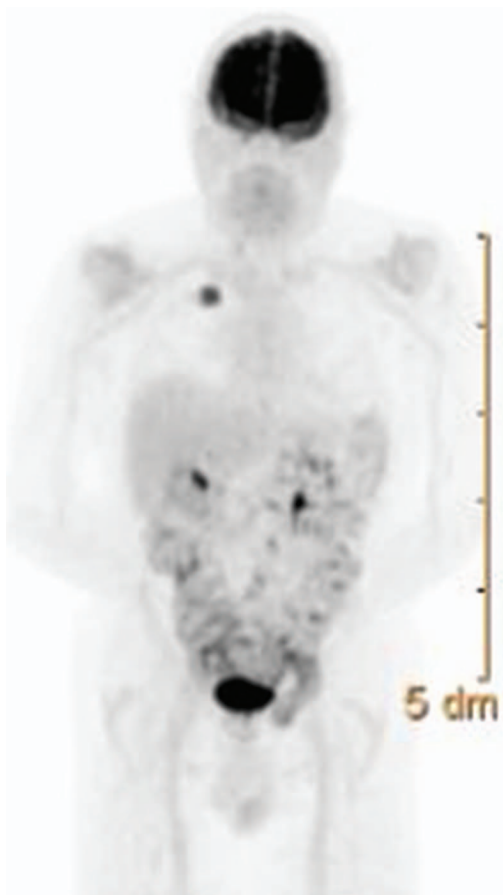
Positron emission tomography scan, notable for increased uptake (SUV 8) in the right upper lobe lesion only.
